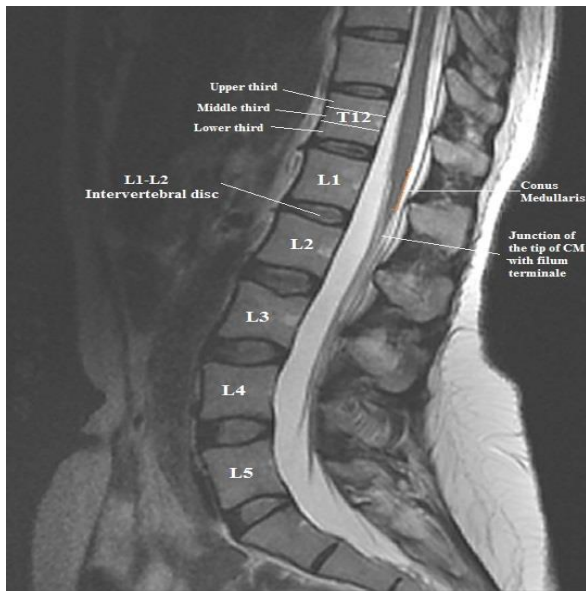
T2-weighted sagittal MRI showing spinal cord, conus medullaris position and its boundaries.
